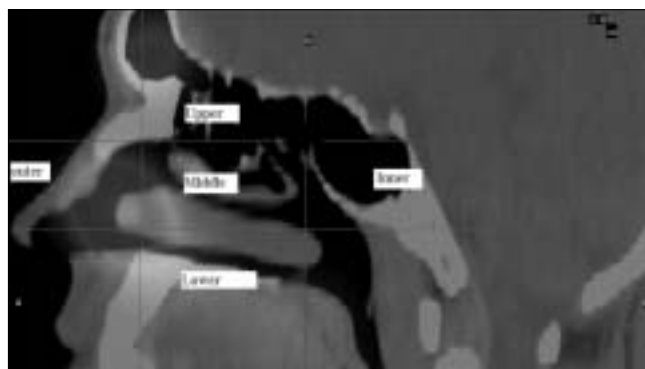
SPECT-CT images showing nasal cavity divisions
